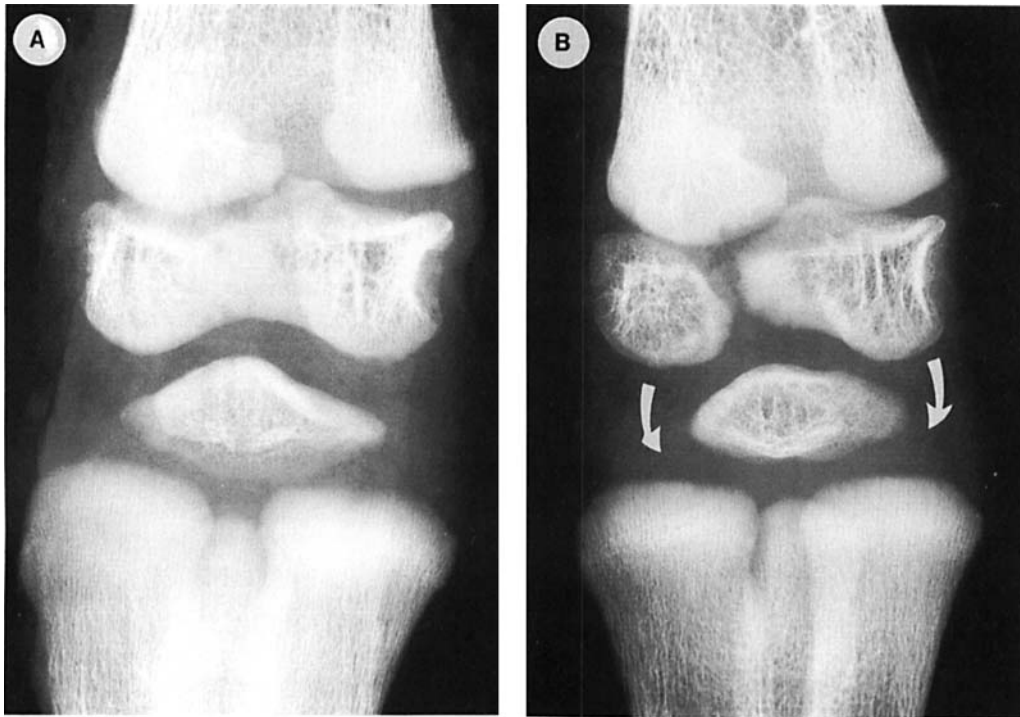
Anterior-posterior microfocal roentgenograms (magnification $\times 5$) of tibiotarsometatarsal (hock) joint: distal end of tibiotarsus (upper) and proximal end of tarsometatarsus (lower); (A) adequate diet: 3 mg pyridoxine-HCl/kg, for six weeks (B) 5-week vitamin B₆-depletion following 1 week of 3 mg pyridoxine-HCl/kg diet. Ossification centres are reduced and bone is less dense. Reduced soft tissue density (arrows) is indicative of ligamentous thinning and synovial oedema.
